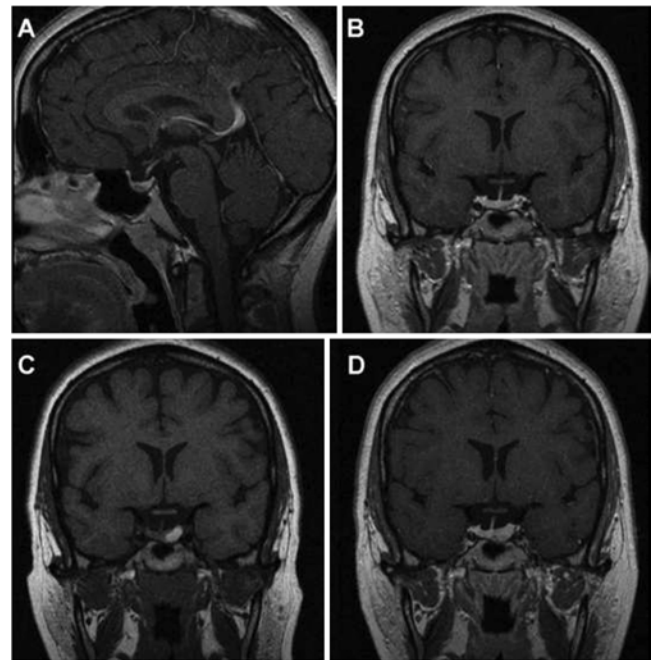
Magnetic resonance images obtained in a 27-year-old woman who was being monitored by the senior author for a pituitary microadenoma who went on to develop pituitary apoplexy. A and B: Sagittal and coronal T1-weighted MR images with contrast enhancement obtained at initial presentation, showing a small adenoma in the left part of the pituitary gland. C and D: Coronal T1-weighted MR imaging studies without and with contrast enhancement, showing hemorrhage into the area of the previously diagnosed tumor. Reproduced from Randall BR, Couldwell WT: *Acta Neurochir (Wien)* 152:1737–1740, 2010, with permission from Springer-Verlag.
